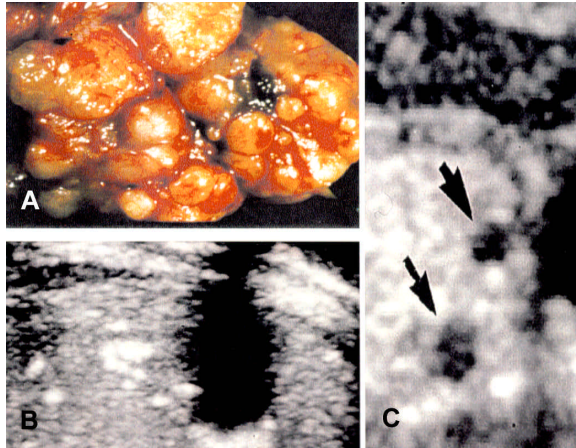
Testicular and thyroid manifestations in Carney complex. Panel a shows a large-cell, calcifying Sertoli cell tumor (LCCST); panel b, sonographic imaging of the testis showing the characteristic calcifications of LCCST (36); panel c, sonographic appearance of the left lobe of the thyroid gland (two hypoechoic lesions are indicated by the arrows) (Picture 4a was given to us by Dr. Carney).
